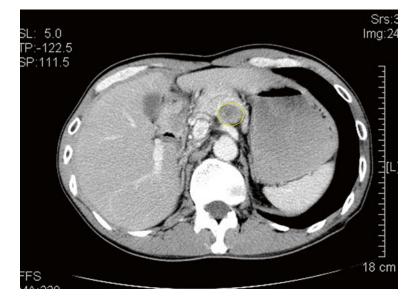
The preoperative CT image of No. 7 LNM (the *circle* represents the swollen No. 7 LNs)
